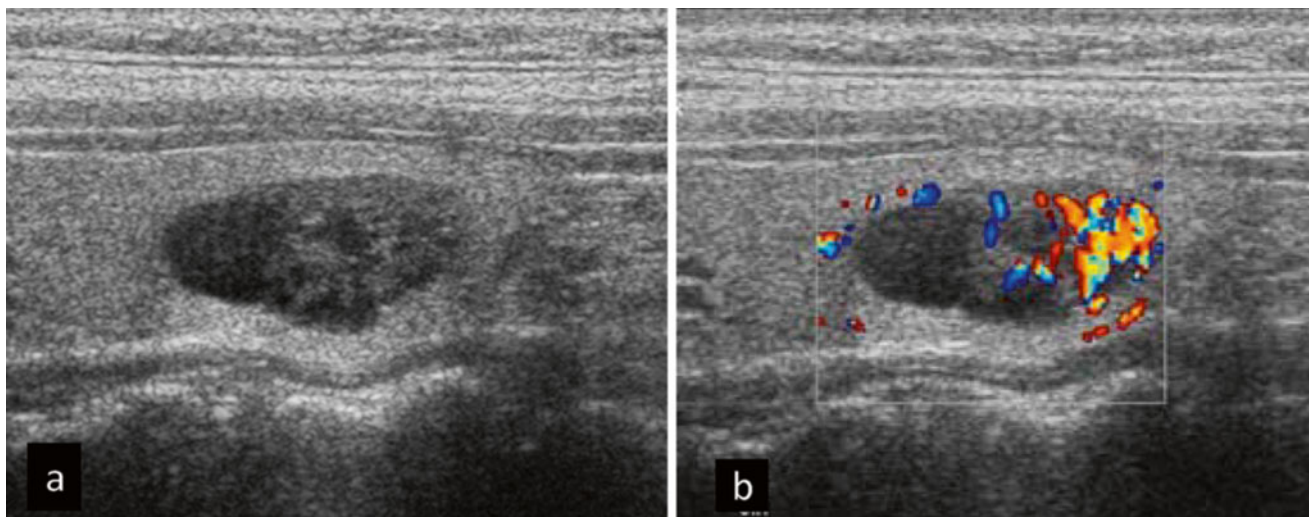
Role of color Doppler US. Sagittal US image of predominantly cystic thyroid nodule with a solid component containing flow. (a) Sagittal gray-scale image shows predominantly cystic nodule with solid-appearing mural component. (b) Addition of color
